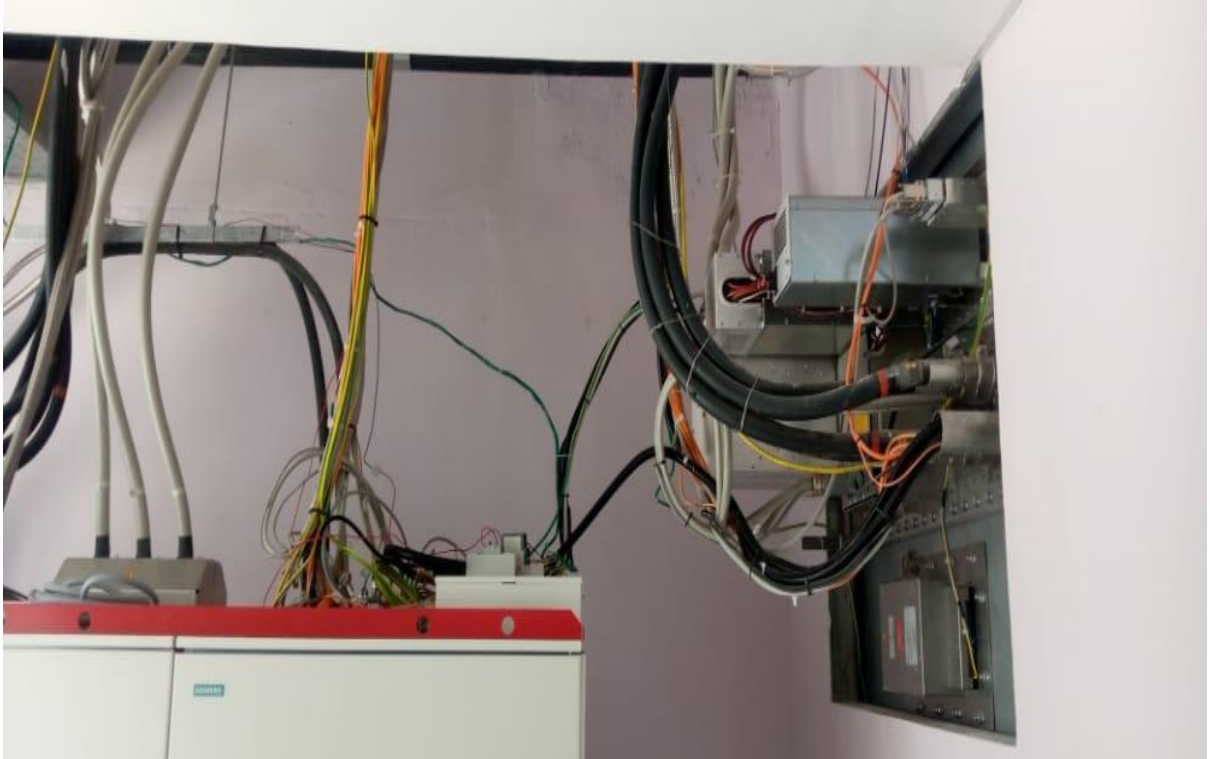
MRI filter panel
